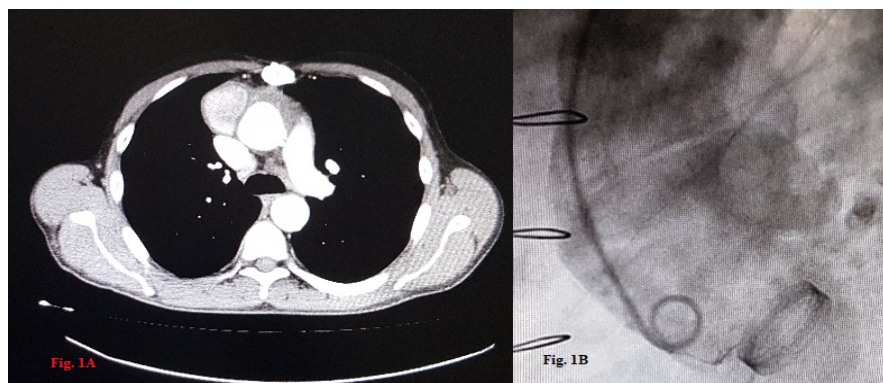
Investigation with CT angiogram and aortogram.
